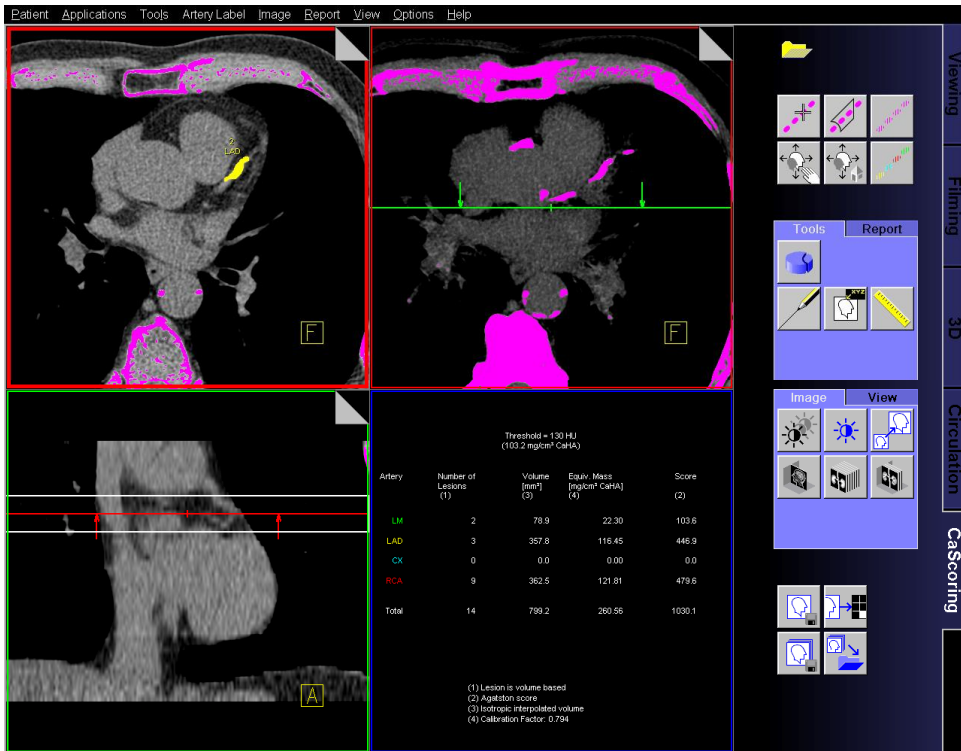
Non-enhanced cardiac CT dataset with at the top right marked calcified plaques in the trajectory of the left anterior descending artery. Color coding is used to color the regions above a certain threshold (typically 130 HU) after which the user indicates which regions are calcified regions inside a coronary artery and to which artery they belong
